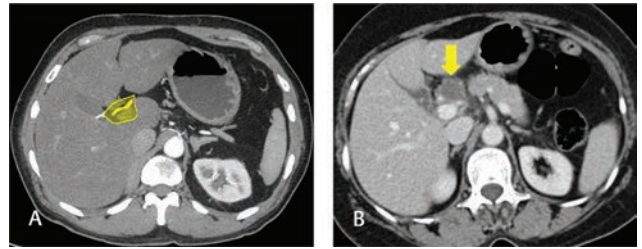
Station 12. Axial CT (A) in arterial phase demarcates station 12: the hepatoduodenal ligament nodes along proper hepatic artery (12a), bile duct (12b), and portal vein (12p) (yellow area in A). Axial CT (B) in venous phase shows a necrotic station 12 node (arrow in B), likely involving the hepatic artery proper, hence unresectable. CT, computed tomography.
